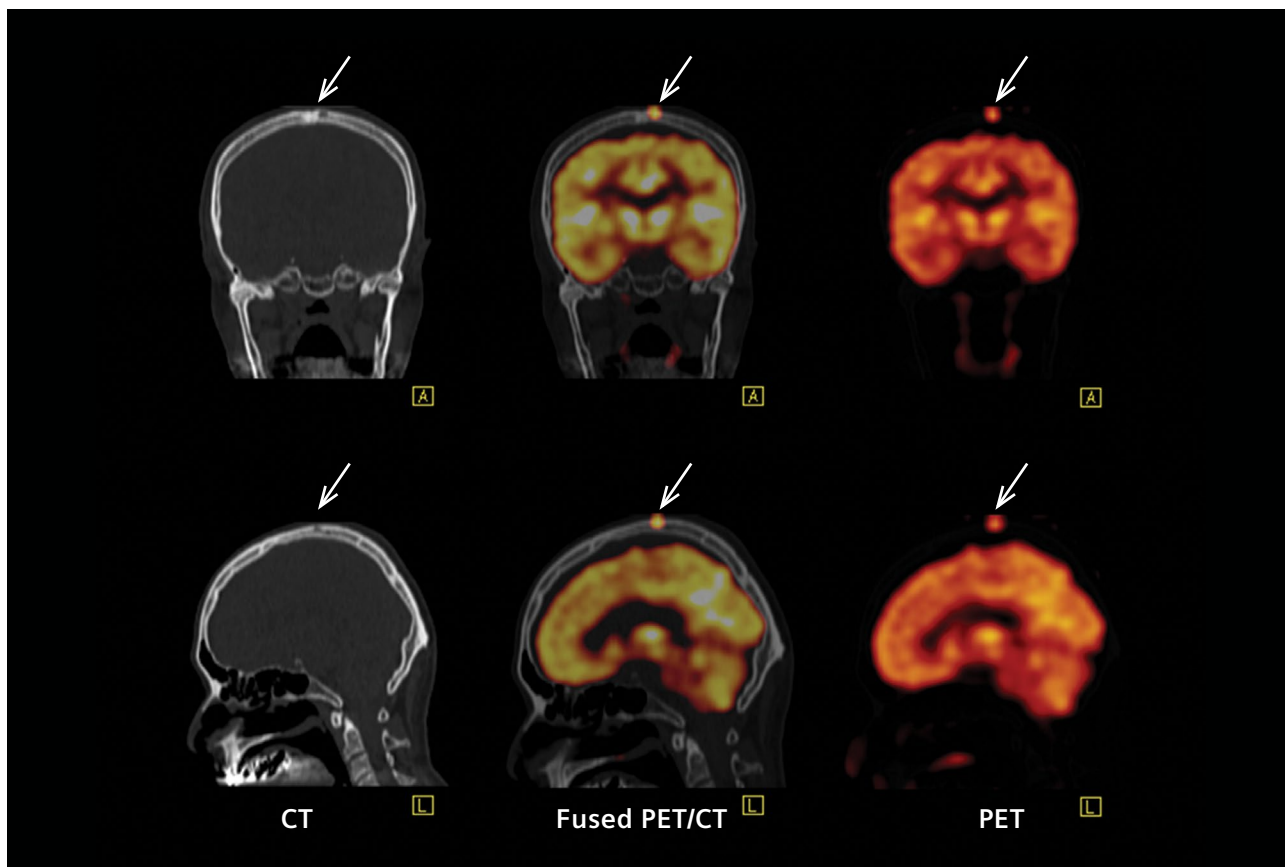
CT, PET and fused PET/CT of the head show a small focal hypermetabolic lesion in the middle of the skull, just left of the midline. CT shows a small lytic lesion involving the outer cortex of the left parietal bone, just to the left of the vertex that corresponds exactly to the focal hypermetabolic lesion on PET—thus suggesting a lytic metastasis.
